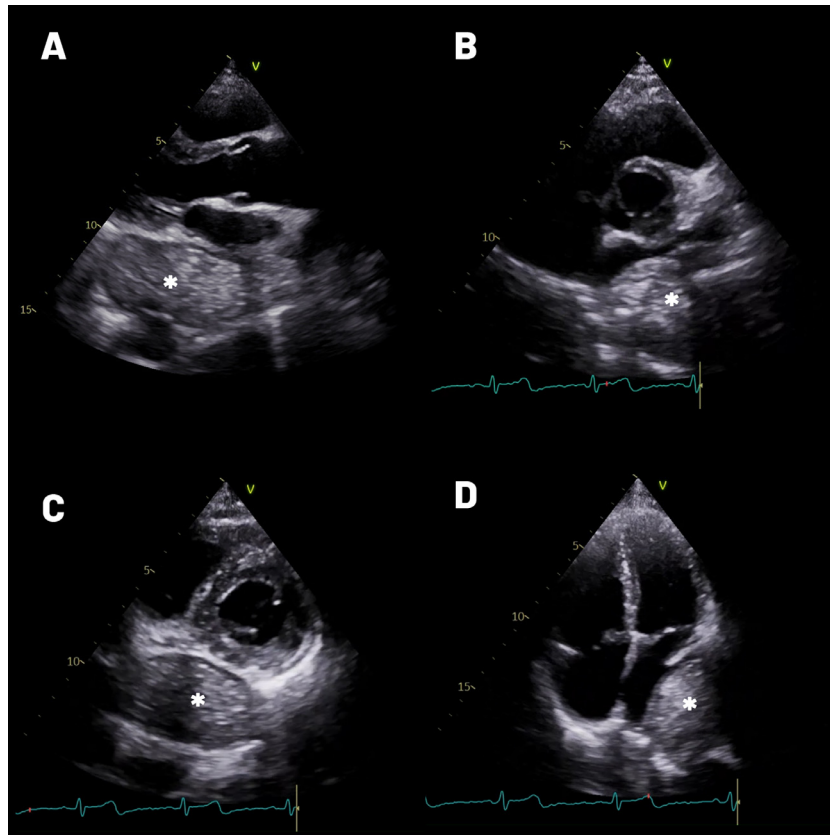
An extracardiac mixed-echo mass (asterisk), located between the posterior wall of the left atrium and the aorta on the parasternal long-axis view (A), on the parasternal short-axis view (B, C), and compressed the left atrium on the apical four-chamber view (D).
